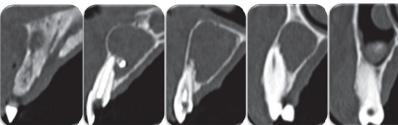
Vertical slices of the CT scan.
